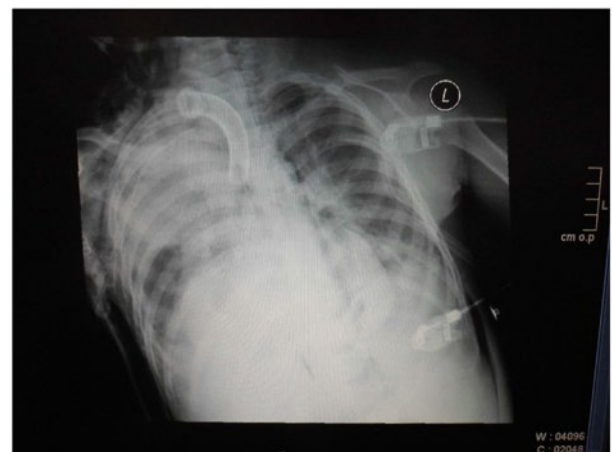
Chest X-ray following the tracheostomy tube insertion.
